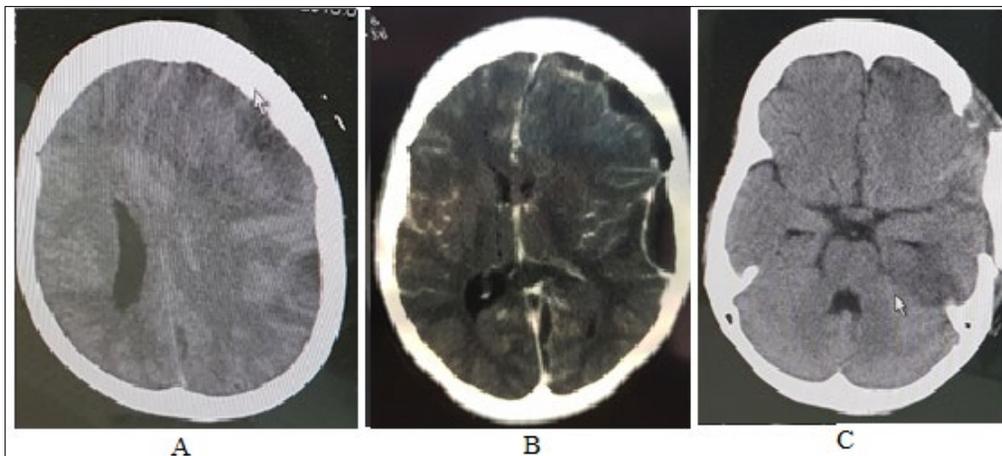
CT cranioccephalic: a) Parenchymal window without injection: hypo-dense left fronto-temporal band; b) Parenchymal window with injection of contractile product: hypo dense collection under durum: empyema; c) Postoperative control: evacuation of the empyema.
